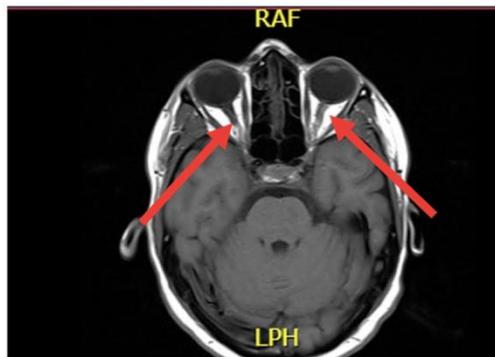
Magnetic resonance imaging showing optic nerve atrophy in both eyes
